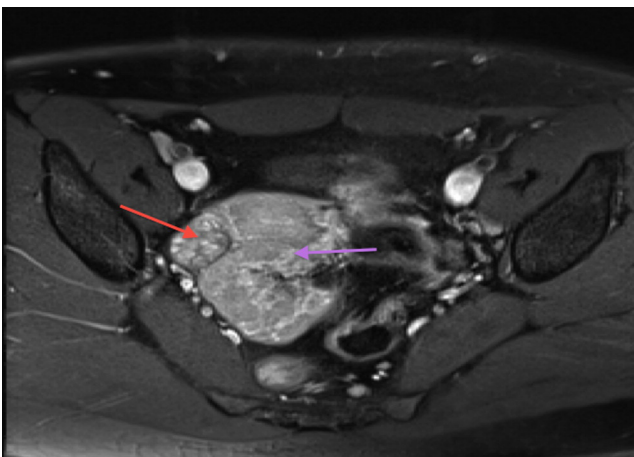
MRI of pelvis, purple arrow at left ovarian mass, red arrow at right ovary.
